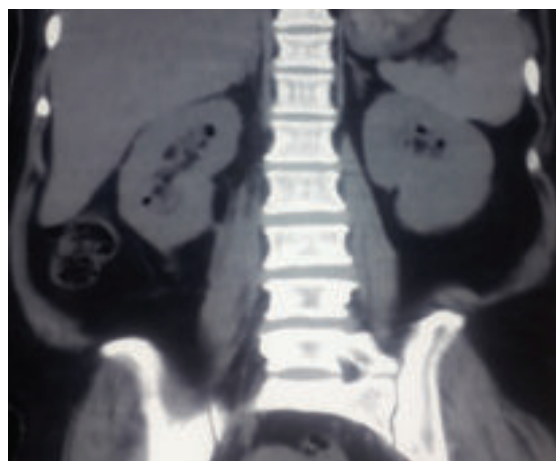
Computed tomography scan (coronal section) showing bilateral emphysematous pyelonephritis
